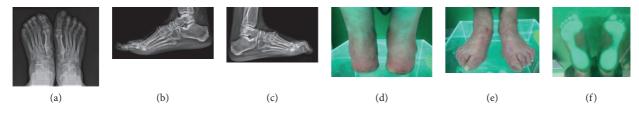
(a–f) Results of imaging tests (X-ray) and podoscopic tests: patient no. 4. (a) Dorsal-plantar foot X-ray: phalangeal valgity, degeneration of the interphalangeal joints, and additional navicular bone in the left foot. (b) Lateral X-ray: coronoid talus bone and degradation lesions in the phalangeal joints. (c) Lateral X-ray: coronoid talus bone and degradation lesions in the phalangeal joints. (d) Posterior picture: ankle joint and hindfoot evaluation. (e) Anterior picture of the feet: assessment of toe positioning and deformation. (f) Plantar photo on the podoscope: assessment of plantar part of the foot and height measurement of the longitudinal arch.
